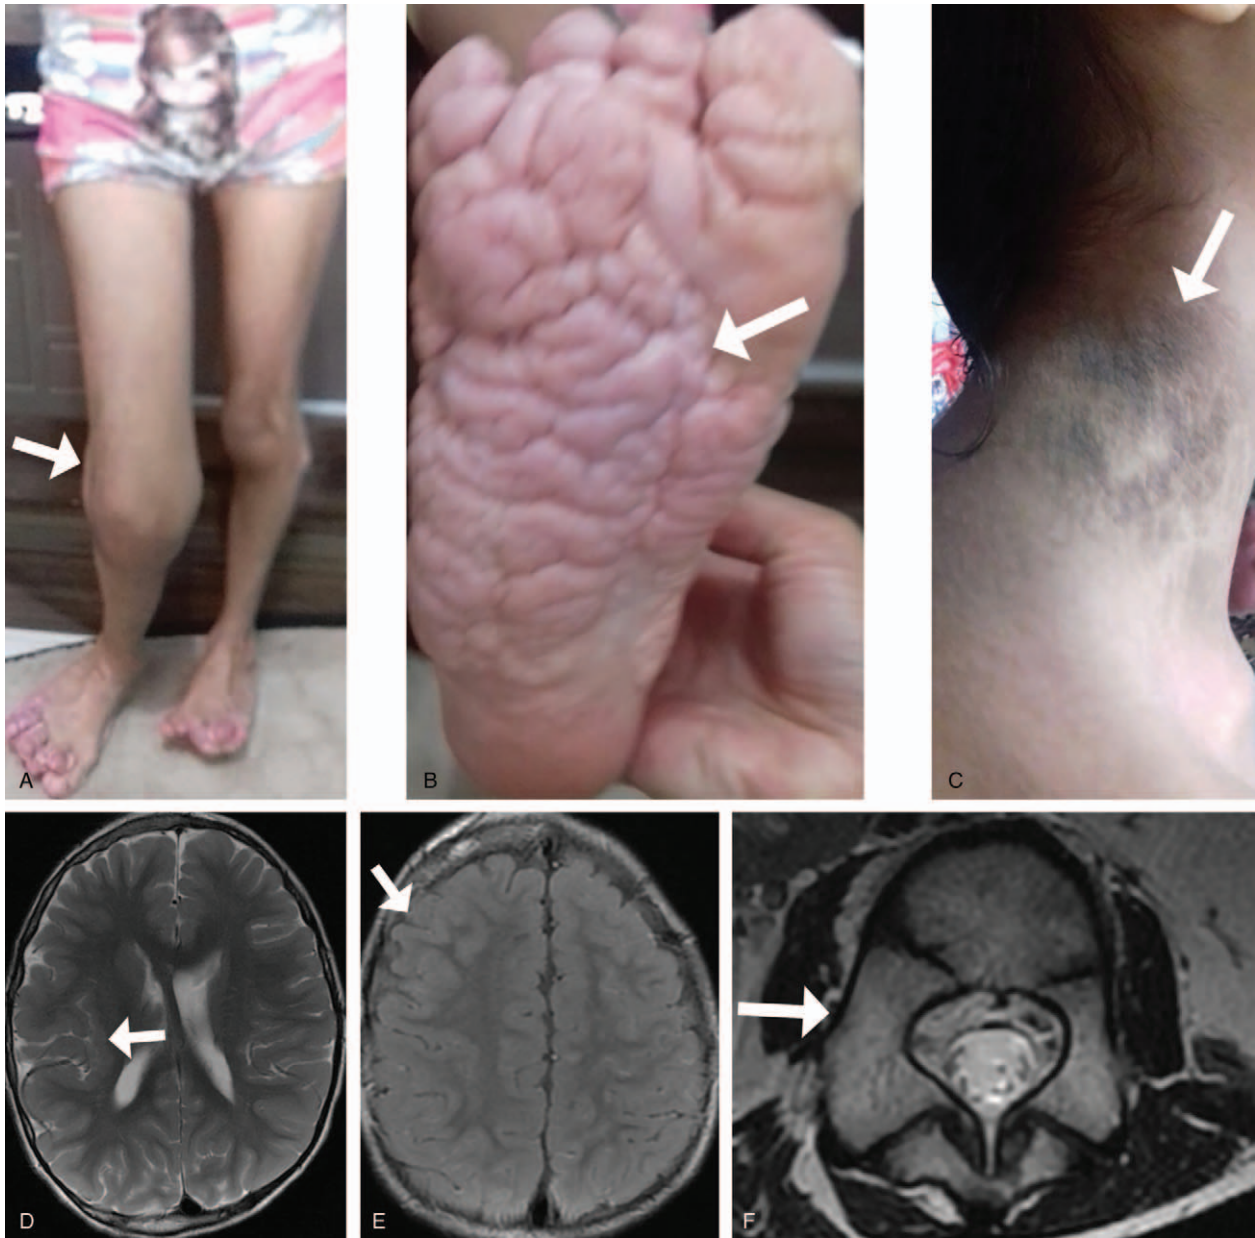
5-Year-old girl with Proteus syndrome. Asymmetric overgrowth of the right leg (white arrow on A). Cerebriiform aspect of the plantar surface of the right foot (B). Epidermal nevi on the right surface of the neck (C). Axial T2-weighted image (D) shows right perisylvian polymicrogyria (white arrow). Axial T2-FLAIR image (E) shows right hemimegalencephaly (white arrow). Axial T2-weighted image of the lumbar spine (F) shows asymmetric overgrowth of a right vertebral pedicle (white arrow).
